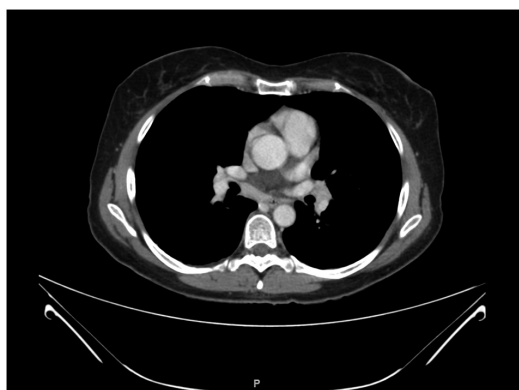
Case number 1. Thoracic CT-scan of February 2020 found out mediastinal lymphadenopathies.
